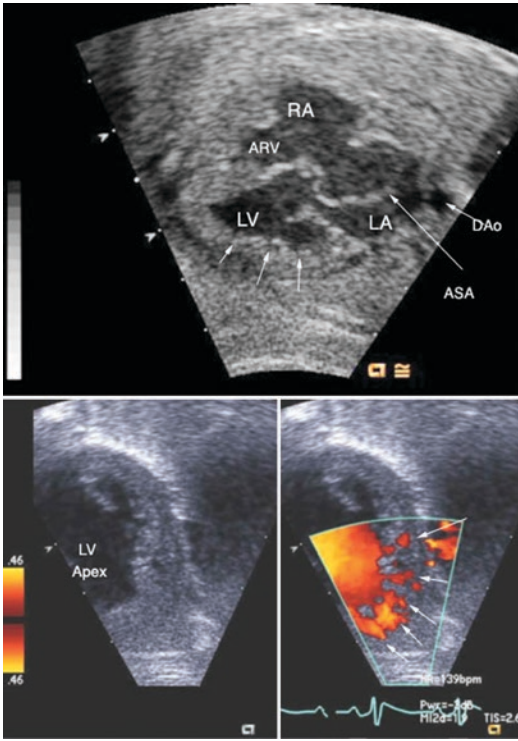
Top.* A Four-chamber image in a 36-week-old fetus with marked enlargement of the right atrium (RA) and an atrial septum which is aneurysmal (ASA), bulging into the left atrium (LA). The left ventricle (LV) demonstrates numerous trabeculations characteristic of spongy myocardium. Only the atrialized portion of the right ventricle is seen in this four-chamber cut because the tricuspid valve was displaced into the right ventricular outflow area. The descending aortic (DAo) lies posterior to the left atrium. *Bottom:* An immediate postnatal echocardiogram demonstrating the spongy trabeculations lying within the apical portion of the left ventricle in this color-compare apical magnified four-chamber cut
